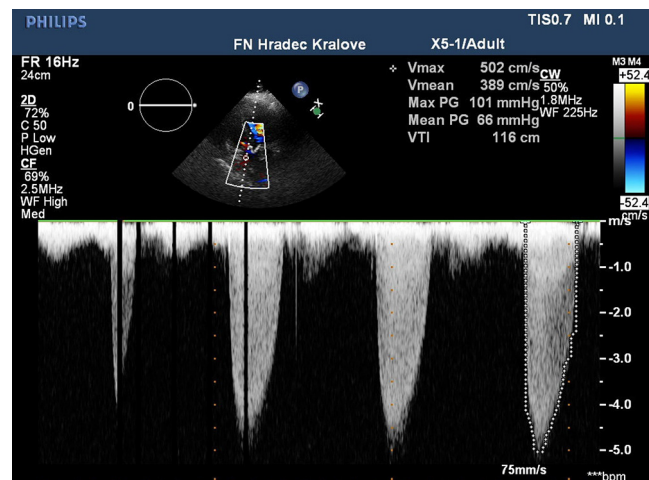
Aortic valve pressure gradient measurement – continuous wave Doppler ultrasound (4AC view with aortic valve).
